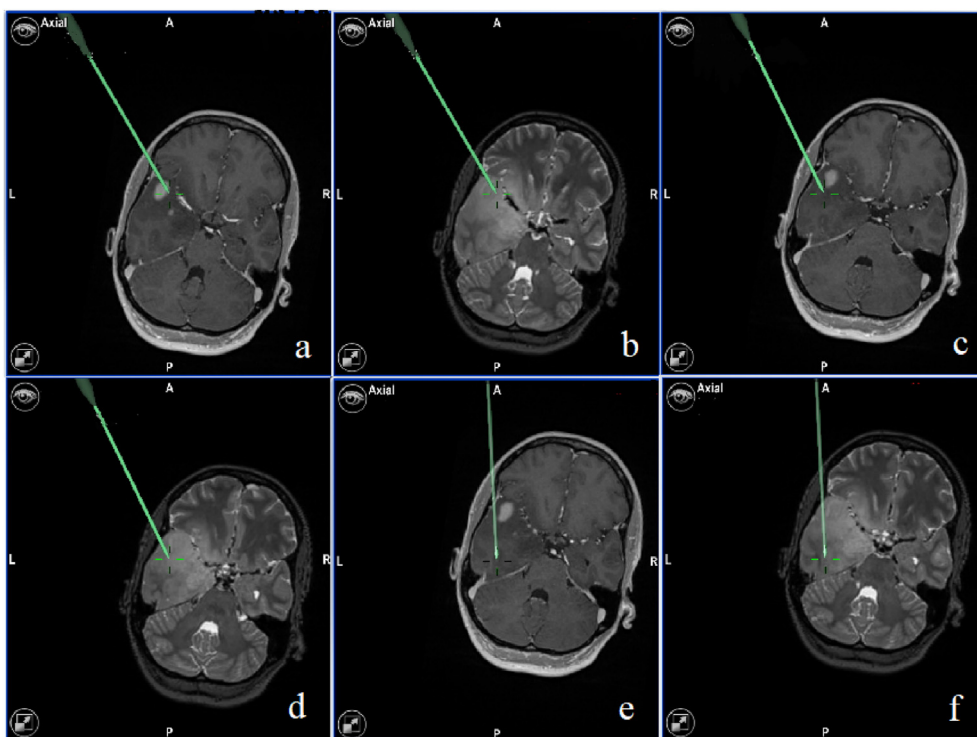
MRI of a patient with anaplastic glioma. The images show different spots, at which the measurements were performed. T1 weighted image (a) and T2 weighted image (b) refer to the same spot within the enhancing part of the tumor with a resistivity value of $4.5 \Omega \cdot m$. T1 weighted image (c) and T2 weighted image (d) demonstrate a measurement spot within the non-enhancing part of the tumor with a resistivity value of $7.4 \Omega \cdot m$. T1 weighted image (e) and T2 weighted image (f) show a measurement spot within the white matter with a resistivity value of $12.3 \Omega \cdot m$.
